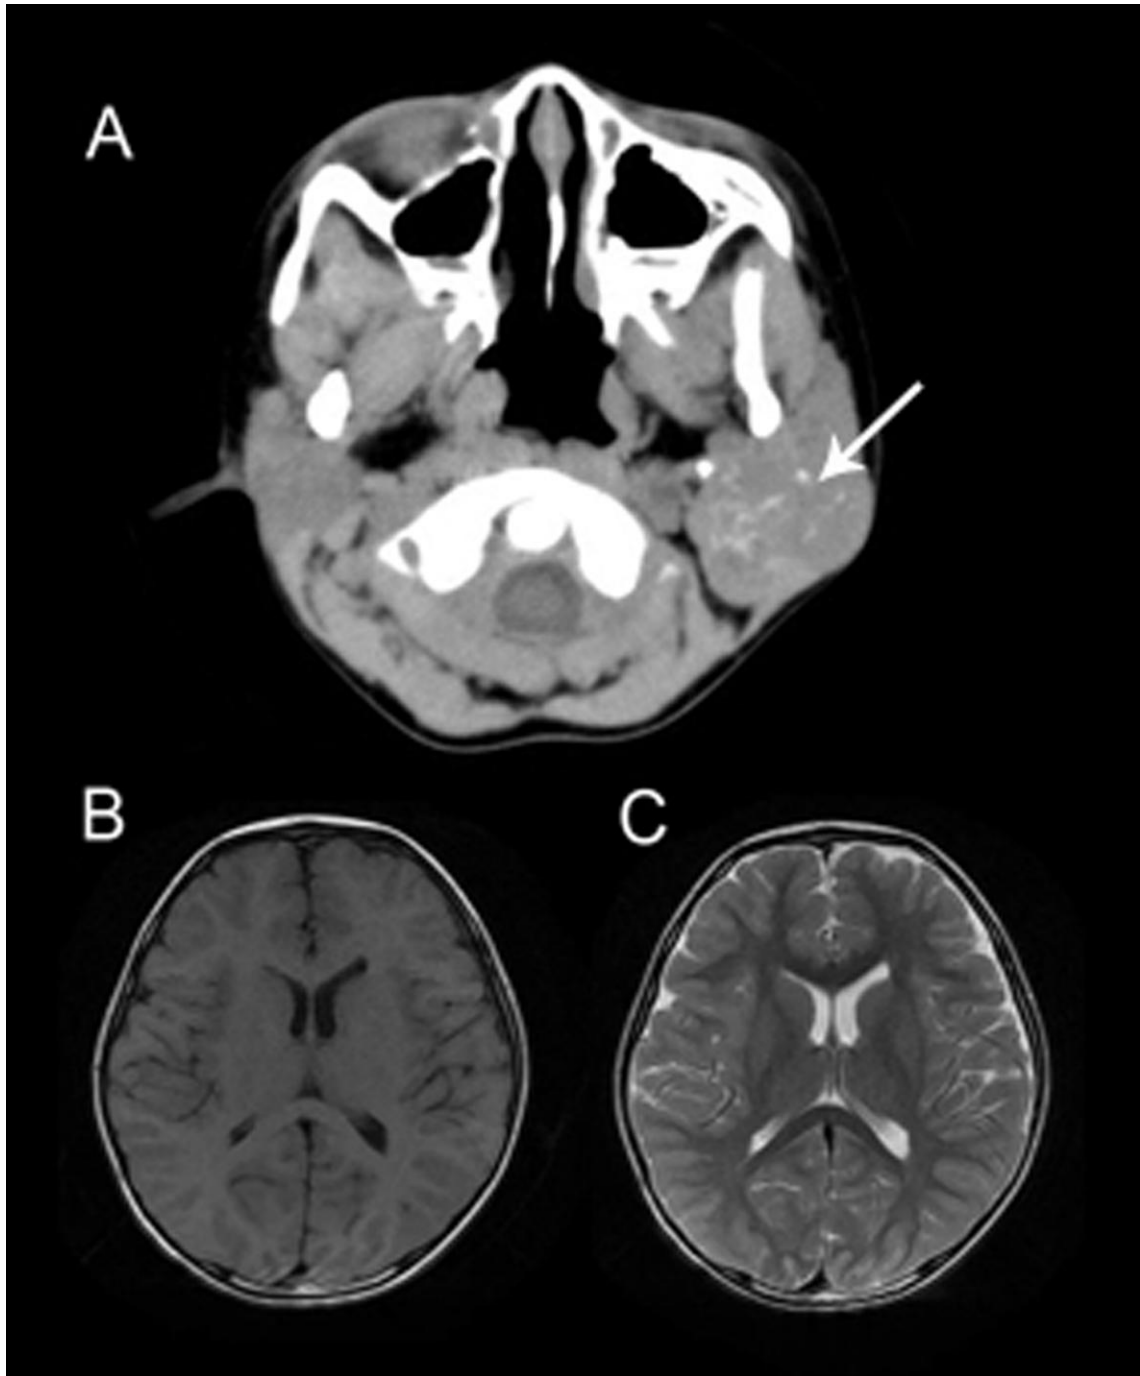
The CT scan which showed a mass located in the deep lobe of left parotid gland. (A) The MRI scan which showed the normal images. (B,C)
